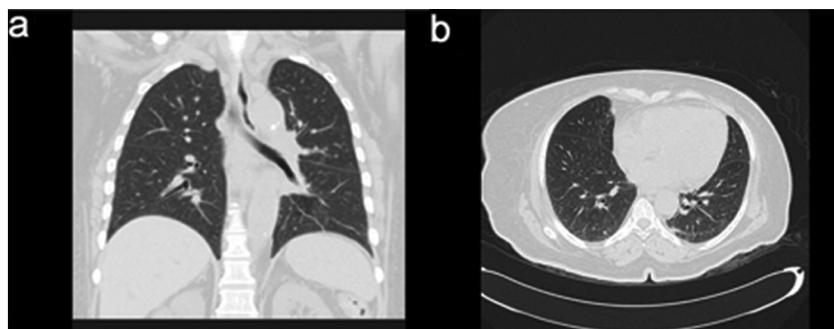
Normal chest computed tomography scan on day 16.
